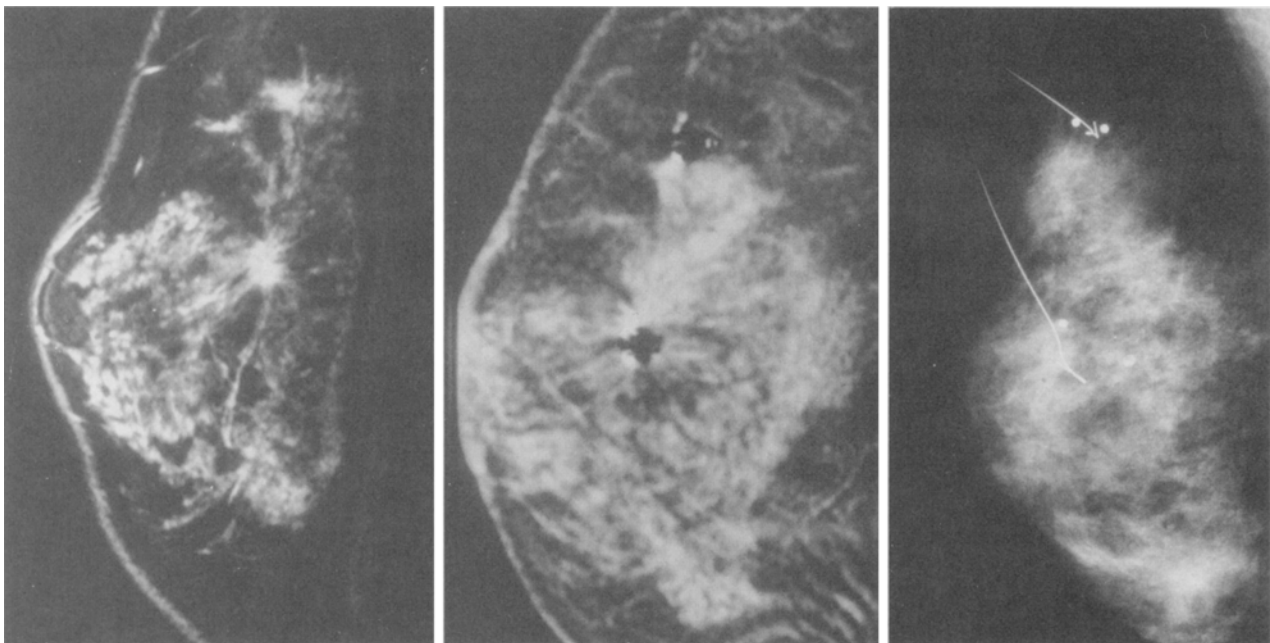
Magnetic resonance imaging (MRI)-guided needle localization and subsequent mammographic appearance of the wire. (A) Two high-intensity lesions that drop out with MRI localization (B). The wires are then demonstrated on mammography (C).
